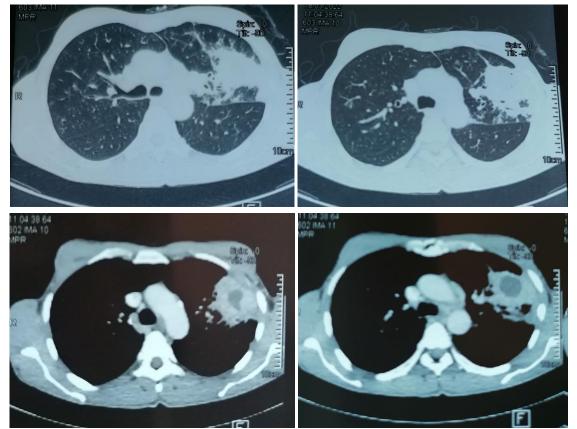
Enhanced computed tomography scan before treatment with lung and mediastinal windowing showing the in homogeneousmass
